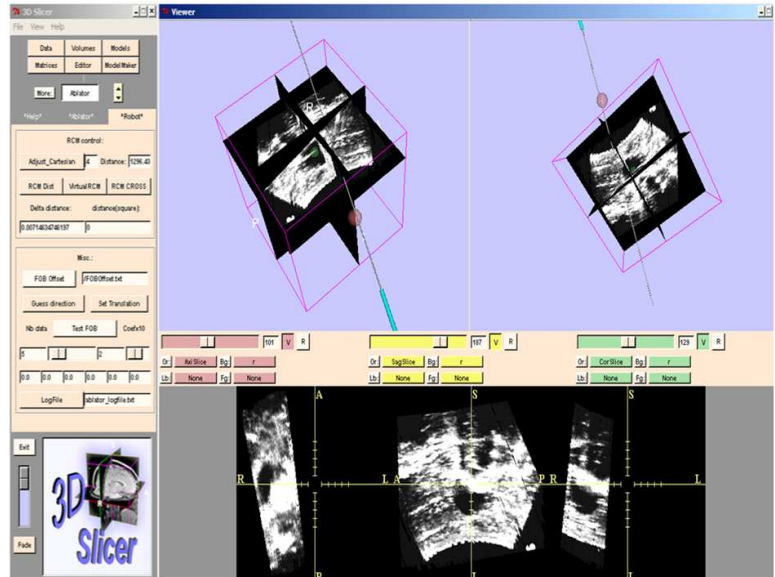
Ultrasound Slicer
